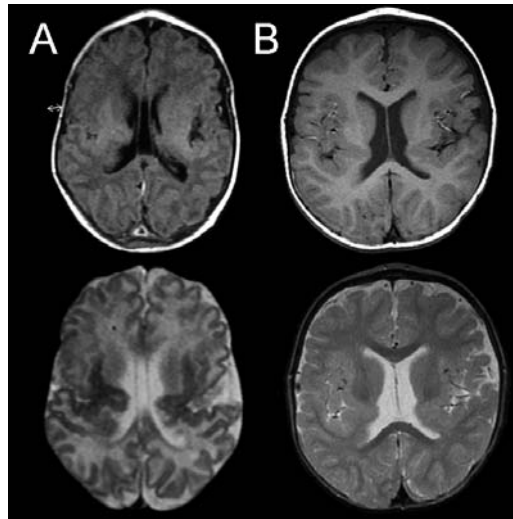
example of changing aspect of polymicrogyria over time in a boy with psychomotor retardation and spastic tetraplegia. A) upper panel T1 weighted and lower panel T2 weighted transversal MRI images at the age of three weeks, and B) the same images at the age of 29 months. Note the difficulty in recognizing the irregular gray-white matter junction in the early MRI. Also note the advanced myelination in the abnormal perisylvian regions, which can be an early indication of a cortical malformation.
